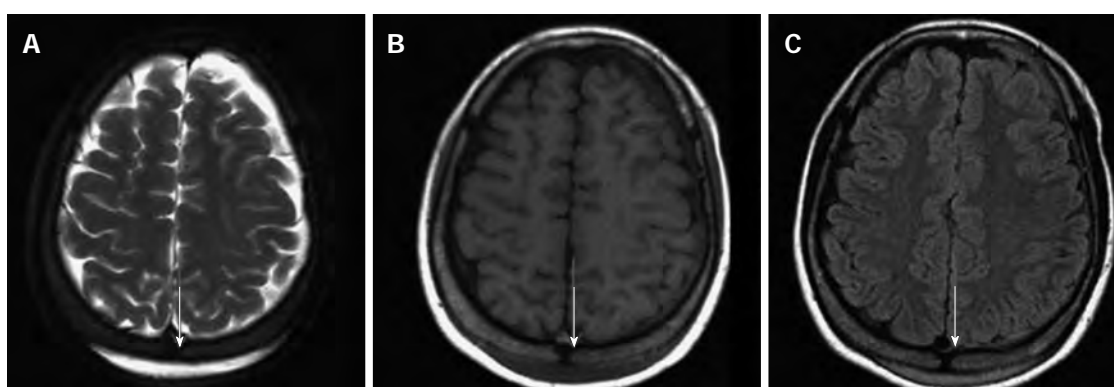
Subgaleal hematoma at the posterior parietal scalp (arrows). A brain magnetic resonance imaging showed a crescentic high signal in the posterior parietal scalp on the T2 weighted image (A), a low signal on the T1 weighted image (B) and mild enhancement on the contrast-enhanced image (C).
